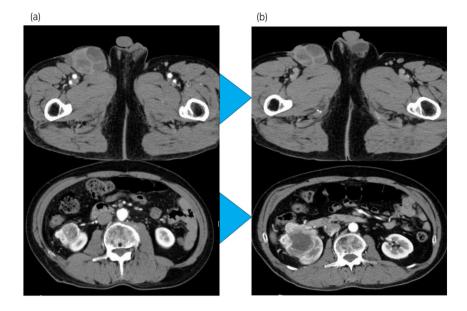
CT findings before (a) and after (b) the initial nivolumab administration. (a) An enlarged right inguinal lymph node and a right renal tumor were initially suspected to be metastases of melanoma. (b) A preoperative CT showed a 52-mm right renal tumor with enhancement mainly at the peripheral lesion. The size of the lymph node metastasis remained unchanged, but the right renal tumor showed enlargement.
